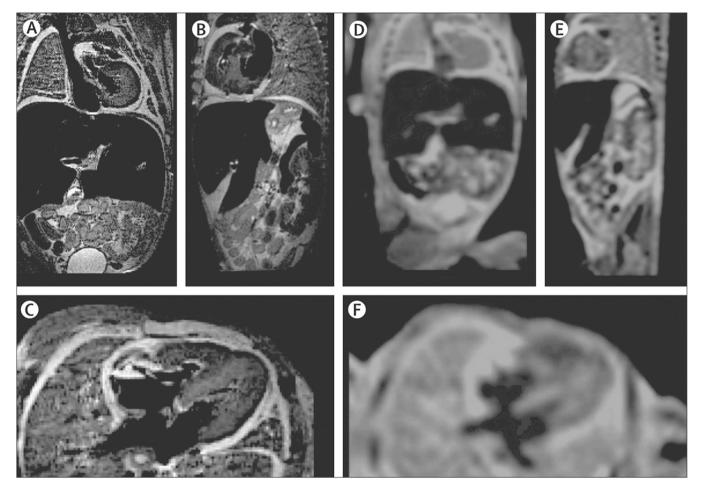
Postmortem fetal imaging using MRI. Fetus obtained after termination of pregnancy at 22 weeks of gestation for skeletal dysplasia. (A) Coronal, (B) sagittal, and (C) axial images obtained with 3D T2-weighted MRI at 9.4 tesla (T). (D) Coronal, (E) sagittal, and (F) axial images obtained with 3D T2-weighted MRI at 1.5 T. Images at 9.4 T showed healthy cartilage and internal organs. Compared to the 1.5T images, the 9.4T images have a higher signal-to-noise ratio (SNR), better spatial resolution and thereby enable more detailed anatomical imaging. Figure adapted from Tayyil et al. 2009 with permission [97].
